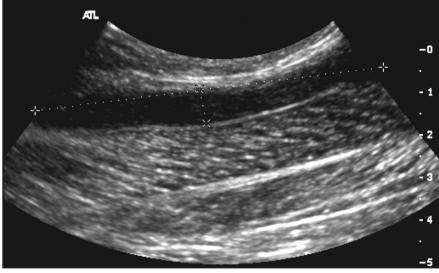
A 34-year-old man with acute left calf swelling. Sagittal gray scale sonographic image of the left calf shows an elongated, relatively hypoechoic collection with debris in the subcutaneous tissues, which is consistent with a hematoma. There was no evidence of either calf or thigh DVT (images not shown).
